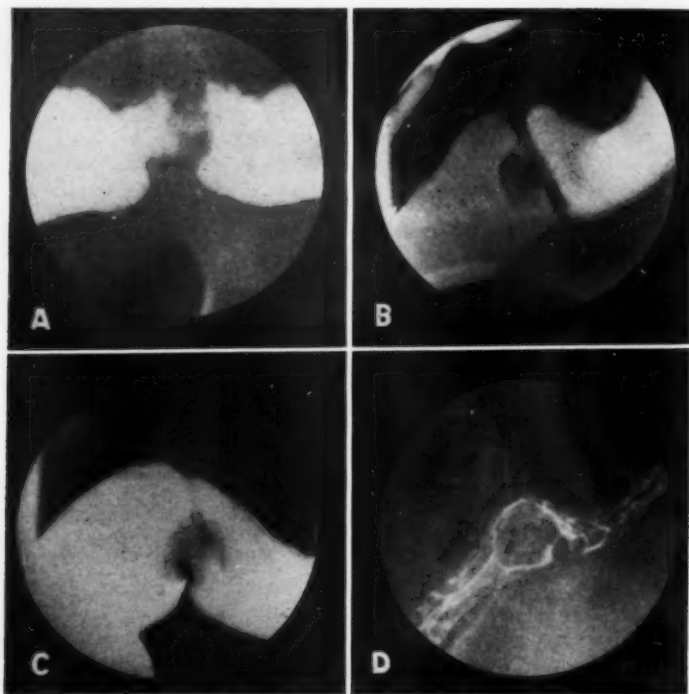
Case VI. A. Four months after operation; probably inflammatory swelling. B. Ten months after operation: suture line and small nodular lesion. C and D. Thirty-one months after operation; irregular polypoid tumor visible on the roentgenograms of the barium-filled and post-evacuation colon.
